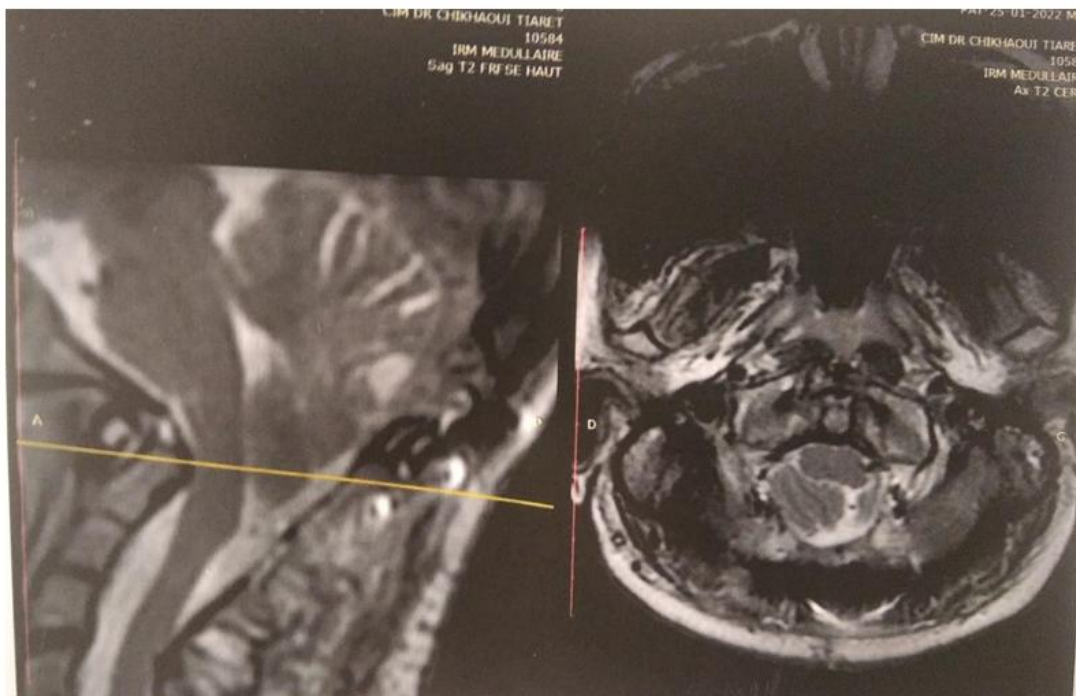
post operative T2-weighted axial MR images and T2-weighted sagittal MR image of the same patient.
